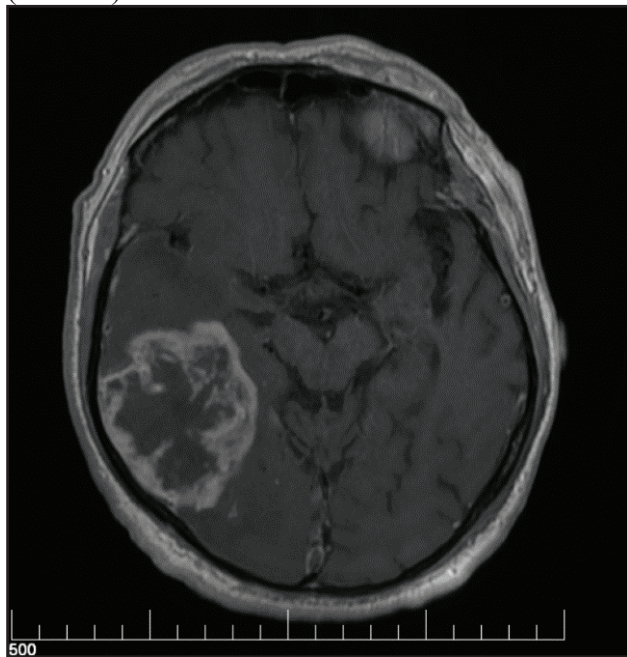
Cranio-cerebral MRI with contrast agent: Expansive intra-neuraxial temporo-parieto-occipital right formation, with subfalcine affliction and right uncus herniation, the imagistic aspect suggesting a multiform glioplastoma.
